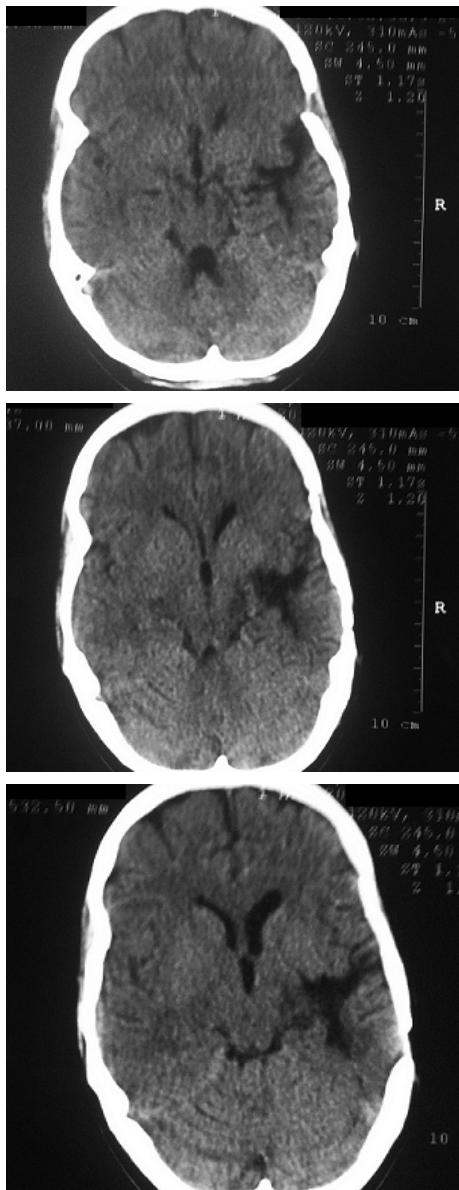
Cerebral CT scan, long term follow-up, normal postoperative aspect
